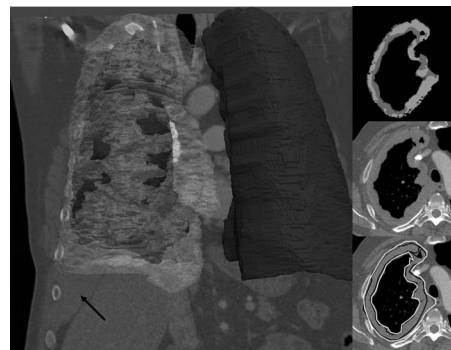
CT scan of a patient with mesothelioma. Left: Lung parenchyma segmentation (dark gray) and mesothelioma segmentation (transparent white) are superimposed. Note that a portion of mesothelioma was incorrectly excluded from the segmentation (black arrow). Right top: Axial cross-section of mesothelioma segmentation. Each gray level represents a different class created by the k-means classifier. Right middle: Axial cross-section of original CT scan. Right bottom: Axial CT cross-section with observer segmentations superimposed: Observer A (white), observer B (black), and observer C (dark gray).
